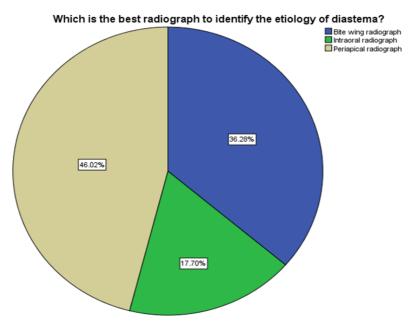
Pie chart showing the responses for the best radiograph to identify the etiology of diastema where blue denotes bitewing radiograph, green denotes
